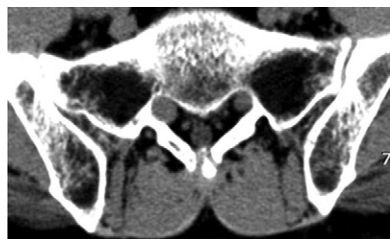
Axial CT reveals isodensity mass around the right S-1 root.
